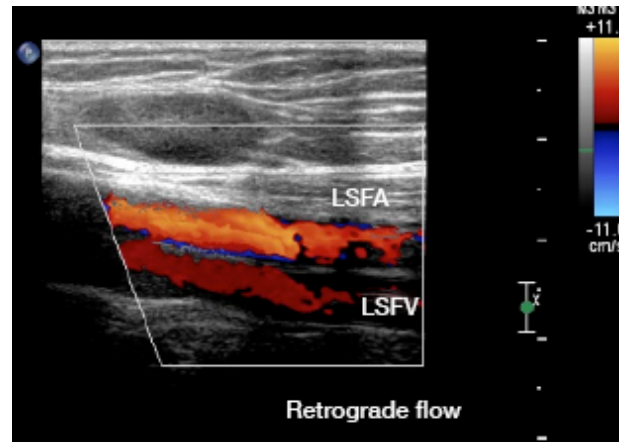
Doppler ultrasound of the left lower limb: superficial femoral vein thrombosis with retrograde flow.
